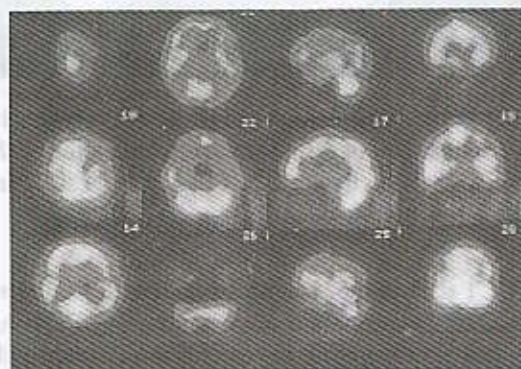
^{99m}Tc -ECD Brain SPECT images of a patient with multiinfarct dementia showing multiple areas of decreased uptake in the left frontoparietal and bilateral parietal lobes.
